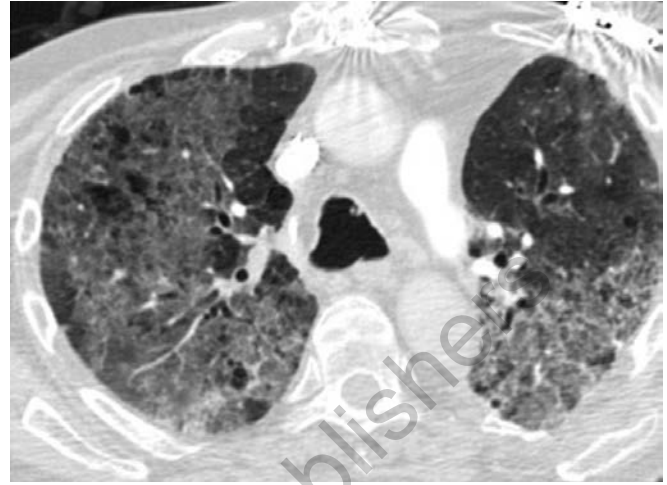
CT chest showing diffuse fibrosis with ground glass attenuation in a patient with drug-induced lung disease
